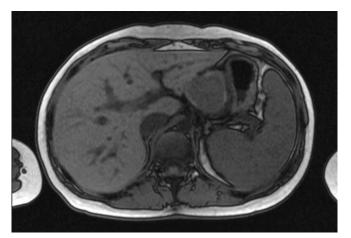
Magnetic resonance imaging showing a subhepatic mass
